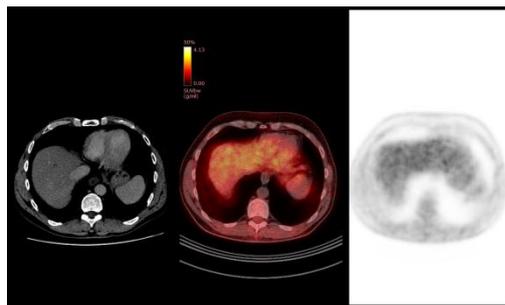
45 years old patient treated of rectal cancer, stage IIIB. Patient was referred to PET/CT due to sub centimetric liver lesion suspected of metastasis. PET/CT did not detect FDG avid lesion. Four months later liver MRI was performed, and metastasis was identified with signs of progression compared to previous CT exam.
